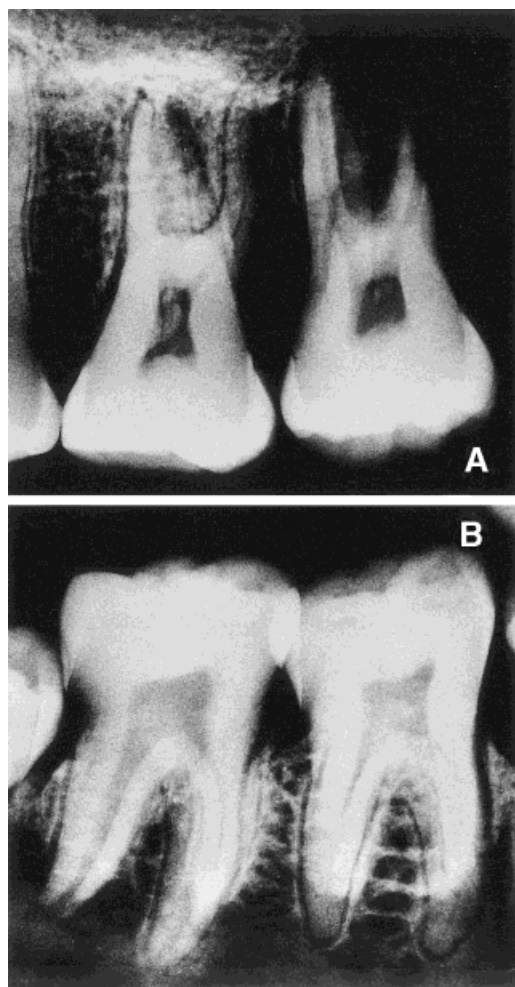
Mesotaurodontism was noted in over 10% of molars. This radiograph of the left maxillary and mandibular first and second molars shows the elongated pulp chamber and root trunk, particularly obvious in the maxilla.
